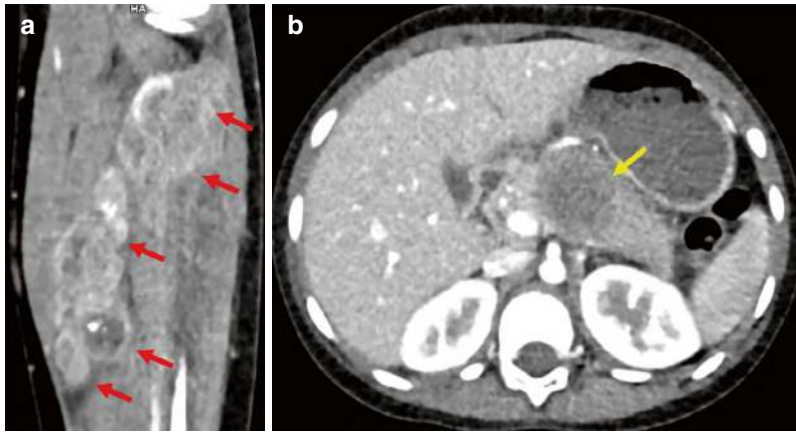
Contrast-enhanced CT in a 6-year-old female with an asymptomatic solitary pancreatic metastasis that developed 3 years after the treatment of primary rhabdomyosarcoma (RMS) in leg. (a) Coronal image depicting
